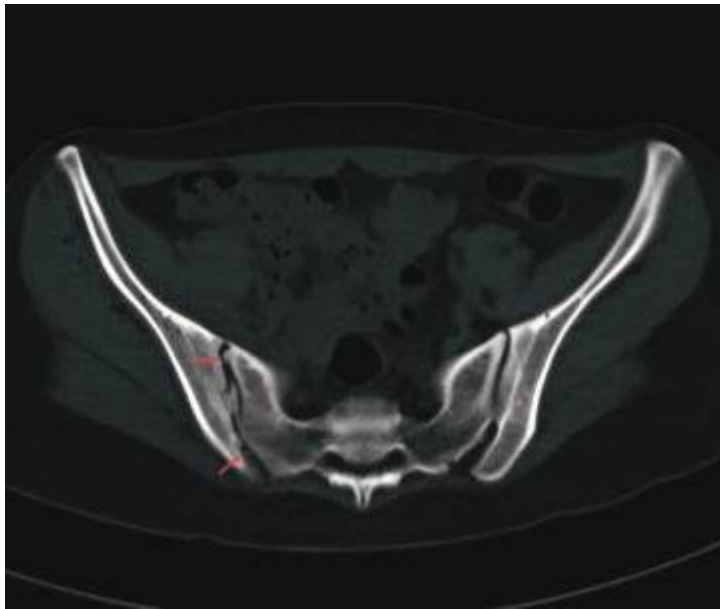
Axial CT image demonstrating unilateral right sacroiliac joint irregularity and cortical erosions, most pronounced inferiorly, consistent with sacroiliitis (arrow).
